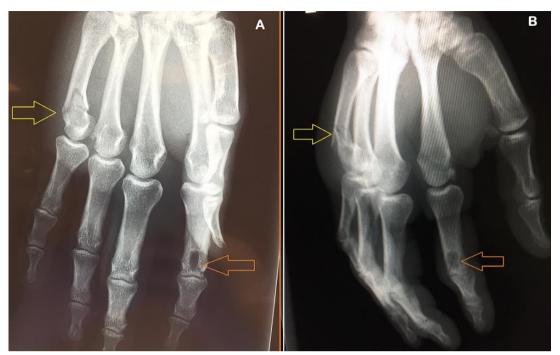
antero-posterior (A) and lateral (B) x-rays of the left hand revealed the boxer's fracture (yellow arrow) and the lytic lesion of the proximal phalanx of the index (red yellow)
